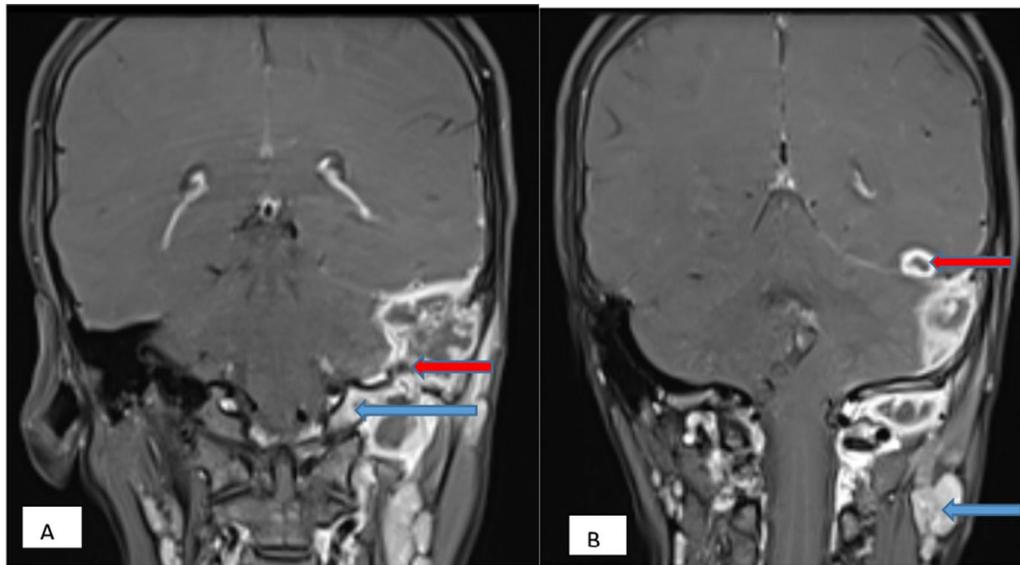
Coronal post-contrast T1 fat-suppressed MR image shows: A) peripherally enhancing soft tissue intensity lesion in left petromastoid temporal bone (red arrow) with extension in left occipital condyle (blue arrow). B) Peripherally enhancing lesion in left temporal parenchyma abutting the tentorium cerebelli (red arrow) with homogenously enhancing enlarged cervical lymph nodes (blue arrow)
